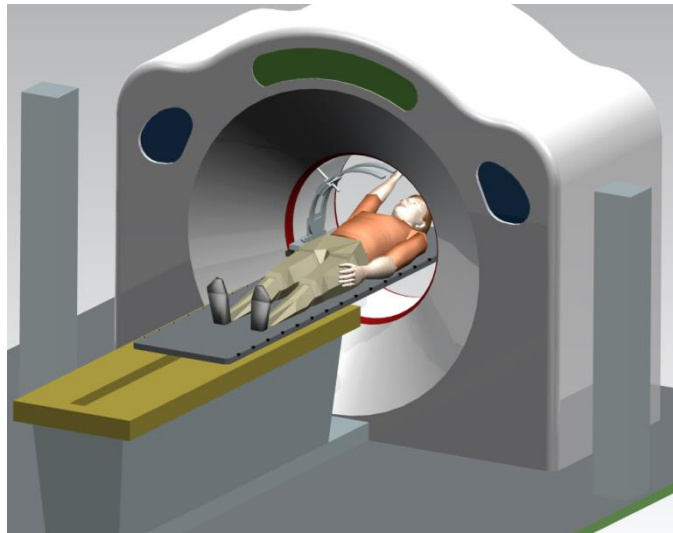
The ATEN robot in the CT-Sim environment
